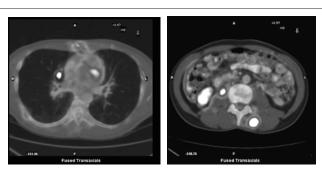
Abnormal increased focal FDG uptake in following multiple intra muscular deposits; (A) Paravertebral muscle on left side at level of L4 and L5 (SUV Max 17.6).
